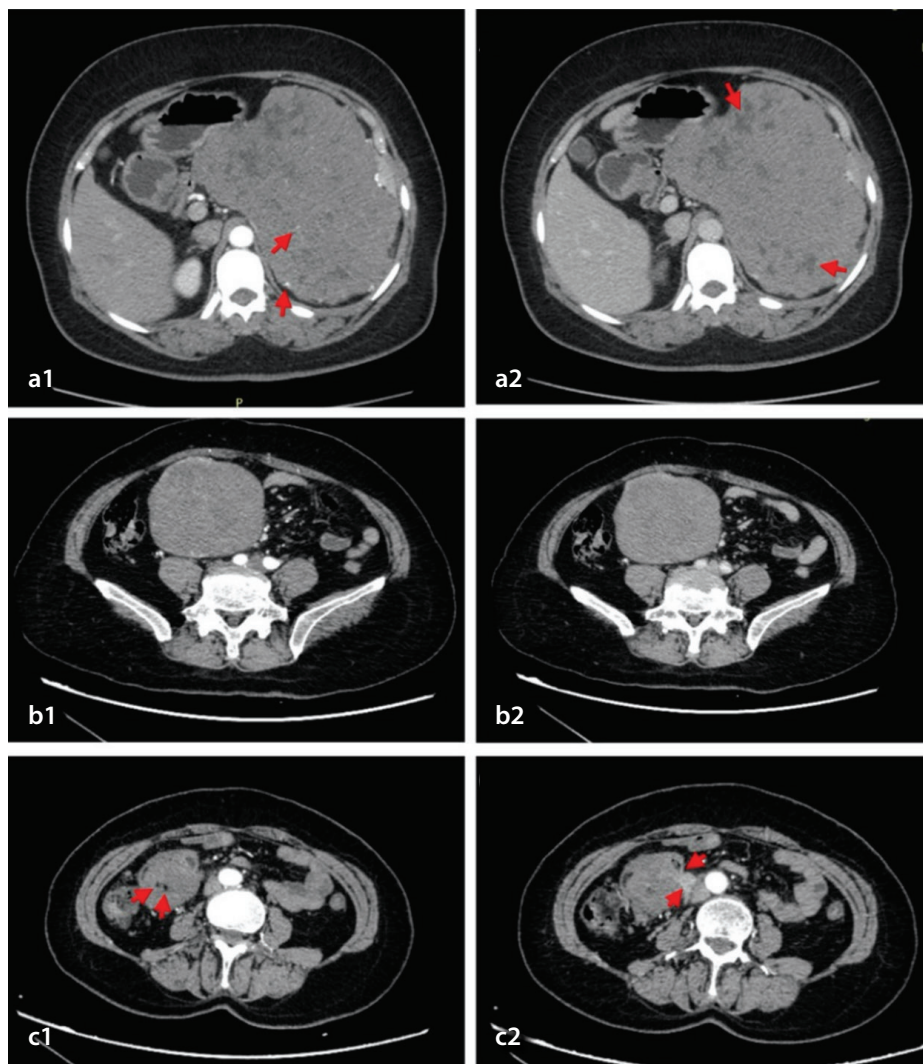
(a) A 50-year-old woman with a 17.1-cm-long diameter extra-gastrointestinal stromal tumor in the space between the stomach and spleen. (a1) Axial arterial phase computed tomography (CT) image revealing an irregular mass with a well-defined border and intralesional vessels (arrows). (a2) Portal venous phase axial contrast-enhanced CT images revealing a heterogeneously enhanced mass with intralesional necrosis (arrows). (b) A 57-year-old woman with a 9.4-cm-long diameter intra-abdominal fibromatosis (IAF) arising from transverse colon mesentery. (b1) Axial arterial phase CT image revealing a regular mass with a well-defined border without intralesional vessels. (b2) Portal venous phase axial contrast-enhanced CT images revealing a homogeneously enhanced mass without intralesional necrosis. (c) A 53-year-old woman with a 5.3-cm-long diameter IAF arising from duodenal mesentery. (c1) Axial arterial phase CT image revealing punctate intralesional fat (arrows). (c2) Axial arterial phase CT image displaying an involved descending duodenal segment (arrow).
